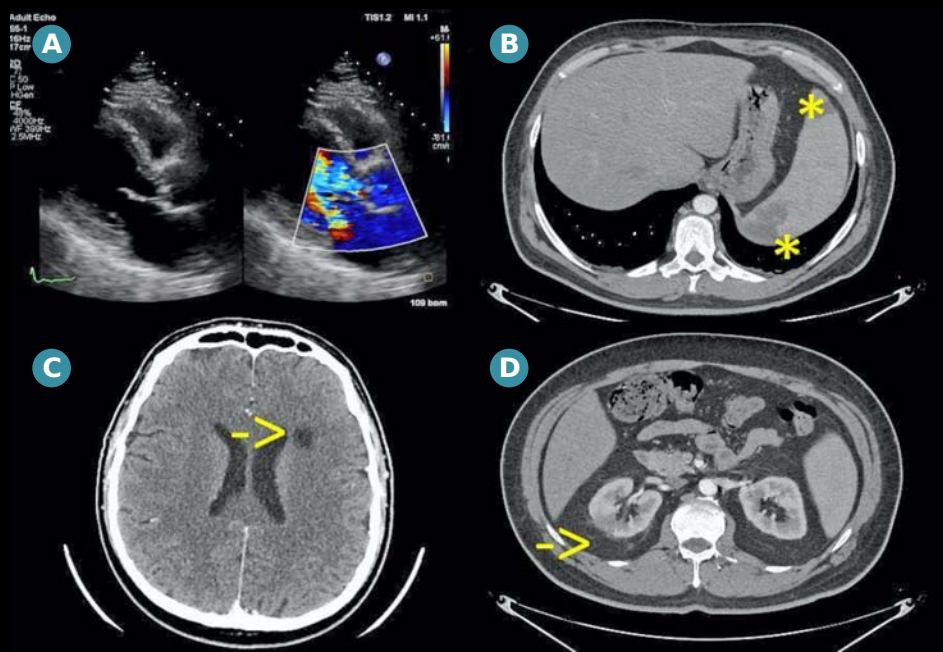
Parasternal long axis 2D and color scan showing morphological changes at the level of the aortic valve and severe aortic regurgitation (A). The CT scan showed cerebral emboli (B) and splenic and renal abscesses (C, D)
